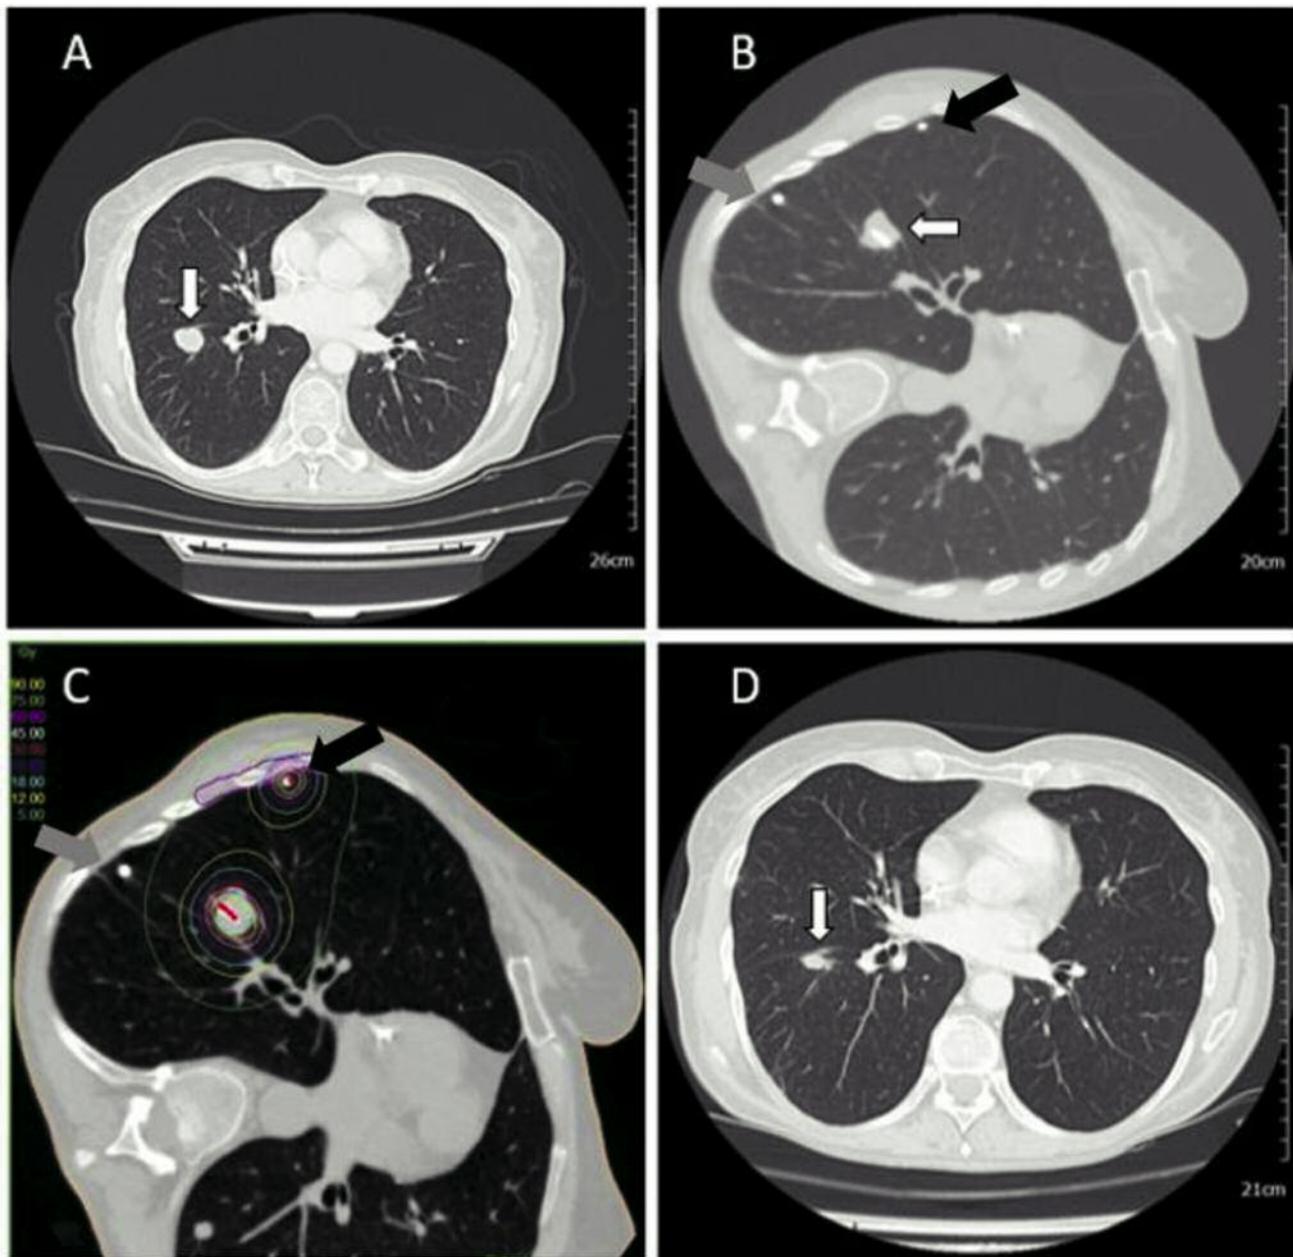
Interventional technique and local tumor control in patient 1 with metastatic anal squamous cell carcinoma (ASCC). A: Pre-interventional contrast-enhanced computed tomographic (CT) slice showing a metastasis of ASCC (white arrow) in the lower lobe of the right lung. The second clinical target volume (CTV) is not depicted in this slice. B: CTV in the lower lobe with one percutaneously implanted brachytherapy catheter (white arrow). A second CTV was located subpleurally in the upper lobe of the right lung (black arrow). C: Planning CT with CTV indicated (red line), catheter (marked in red) and isodose lines for both CTVs in the lower and middle lobe (black arrow). D: Contrast-enhanced CT slice 3 months after interstitial brachytherapy showing partial remission of the treated lesion in the lower lobe (white arrow). The second CTV is not depicted in this slice. Gray arrows: Chest drain.
